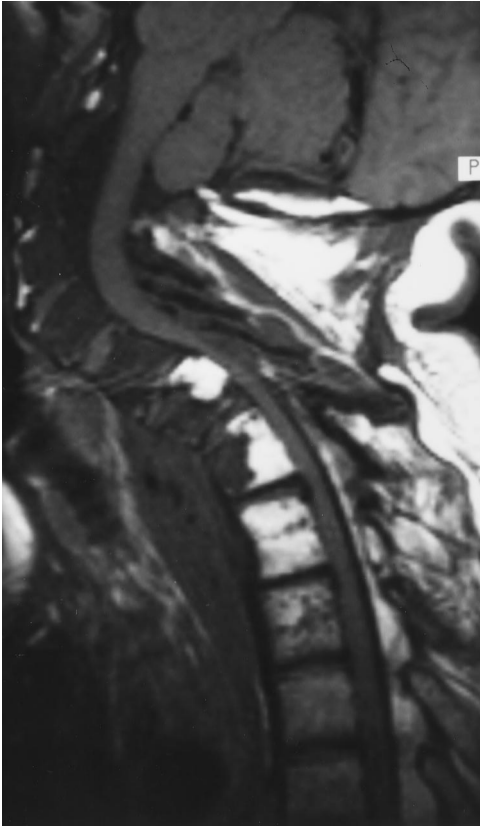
Case 1. Magnetic resonance imaging of the cervicothoracic spine. Note severe kyphotic deformity with cord compression from C5 to T1.
